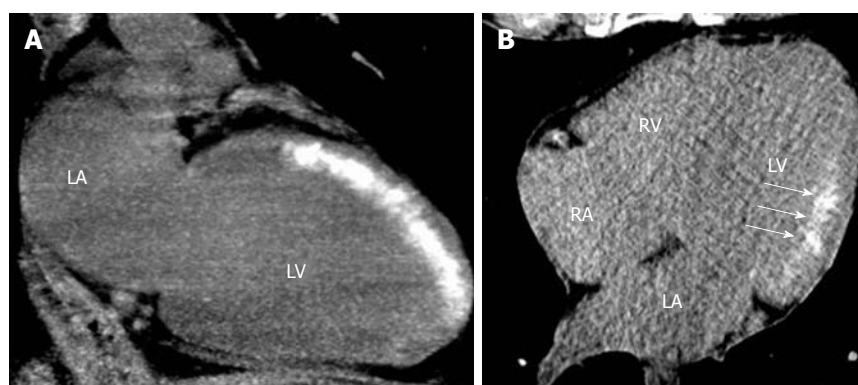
Early assessment of myocardial viability immediately after primary percutaneous coronary intervention in patients with anterior (A) and inferolateral (B) ST-segment elevation acute myocardial infarction. Delayed enhancement of iodinated contrast administered during percutaneous coronary intervention is observed using non-contrast enhanced cardiac computed tomography, without heart rate control and using a low dose-saving protocol. Discrimination between transmural (A) and subendocardial (B, arrows) extent of the irreversible myocardial damage (delayed enhancement) can be achieved using this technique. LA: Left atrium; LV: Left ventricle; RA: Right atrium; RV: Right ventricle.
